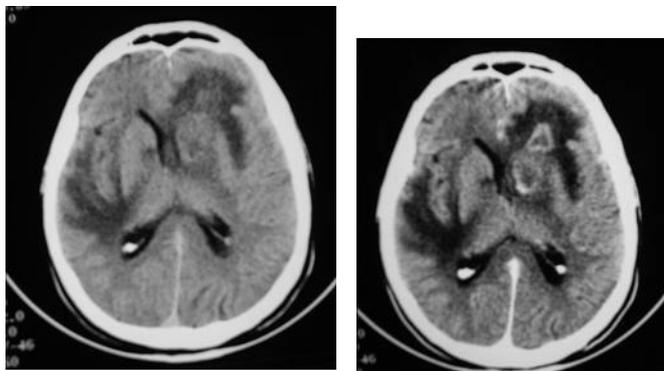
Brain CT of patient with AIDS and TE.
